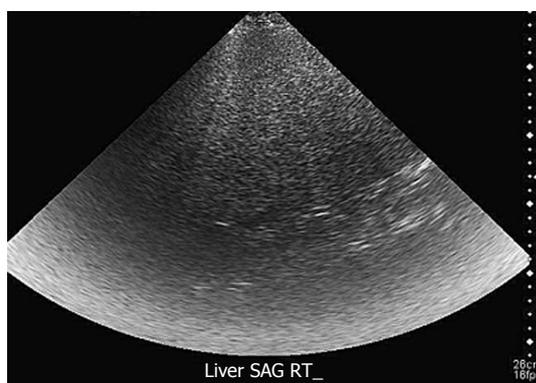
Sagittal ultrasound image of the liver shows diffuse liver steatosis. Data adapted from Yokoo *et al*^[79].
